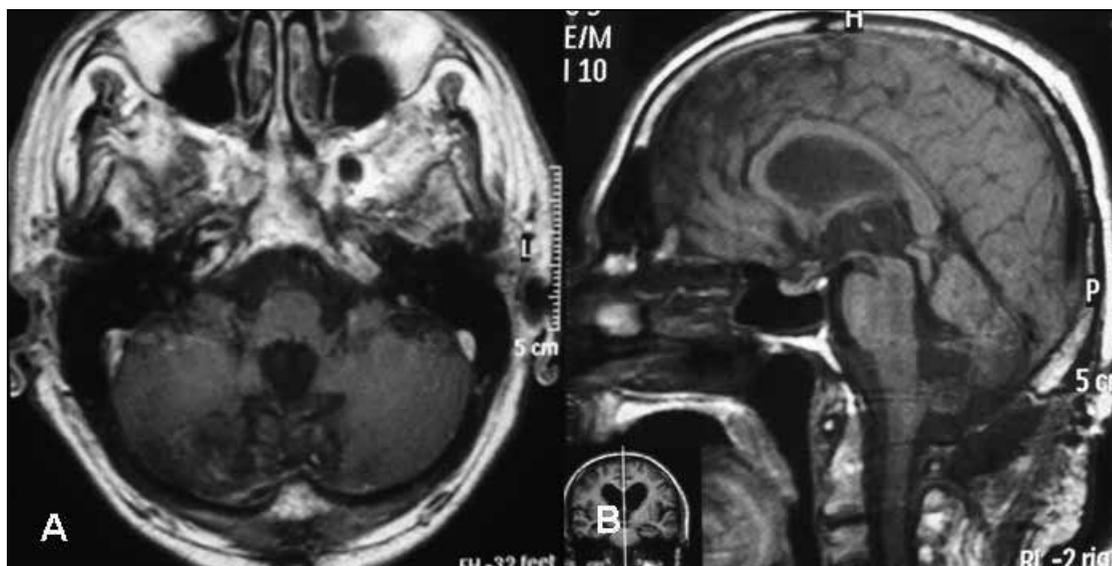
Post-contrast enhancing MRI demonstrating no residual tumor and decompression of the brain stem, with regression of the hydrocephalus. A) axial and B) sagittal images.
